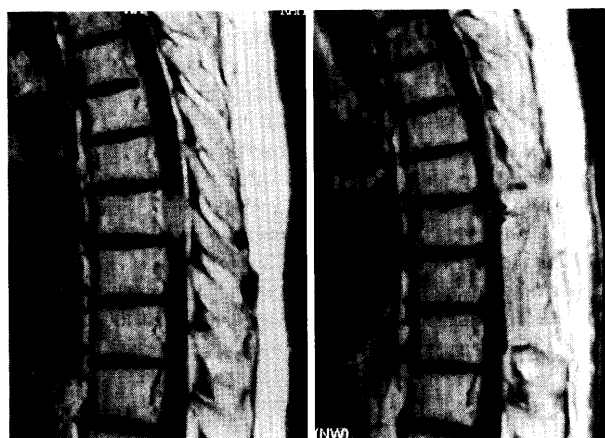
Case Two. Sixty-year-old female. Meningioma at T9. Pre (*right*) and postoperative (*left*) MRI.
